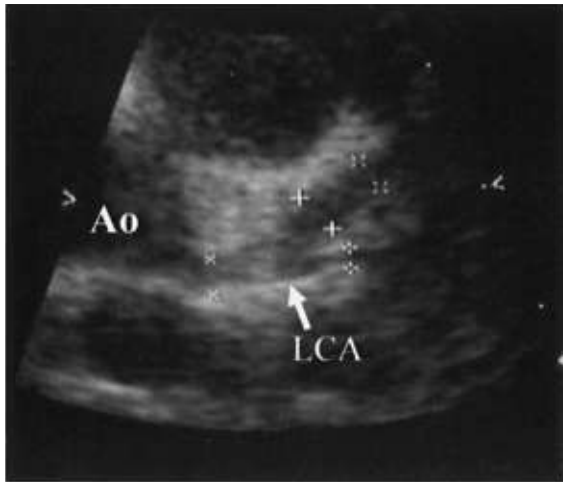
Left coronary artery on echocardiography. The left coronary artery had expanded to a diameter of 3.5 mm.
